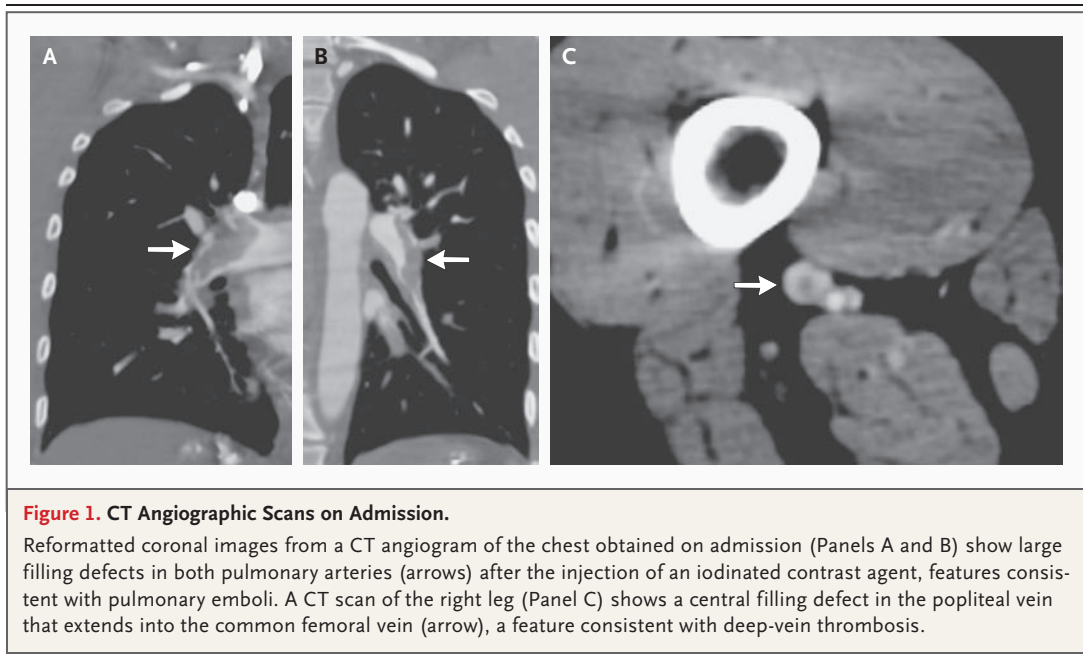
CT Angiographic Scans on Admission.
